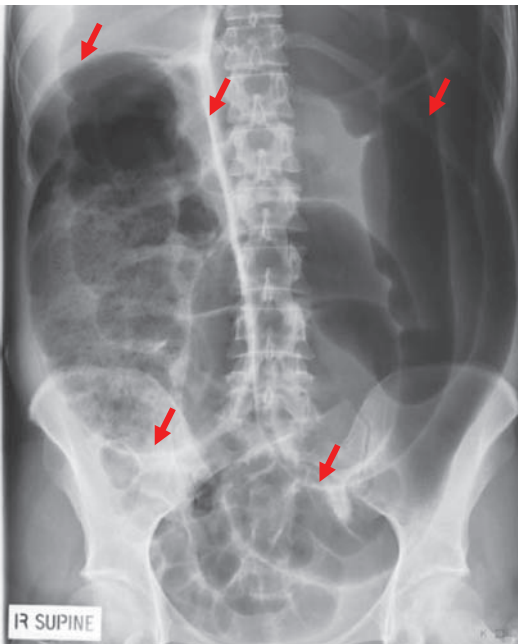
Plain supine abdominal x-ray of sigmoid volvulus (arrows showing margins of volvulized sigmoid loop in a background of dilated proximal bowel).
